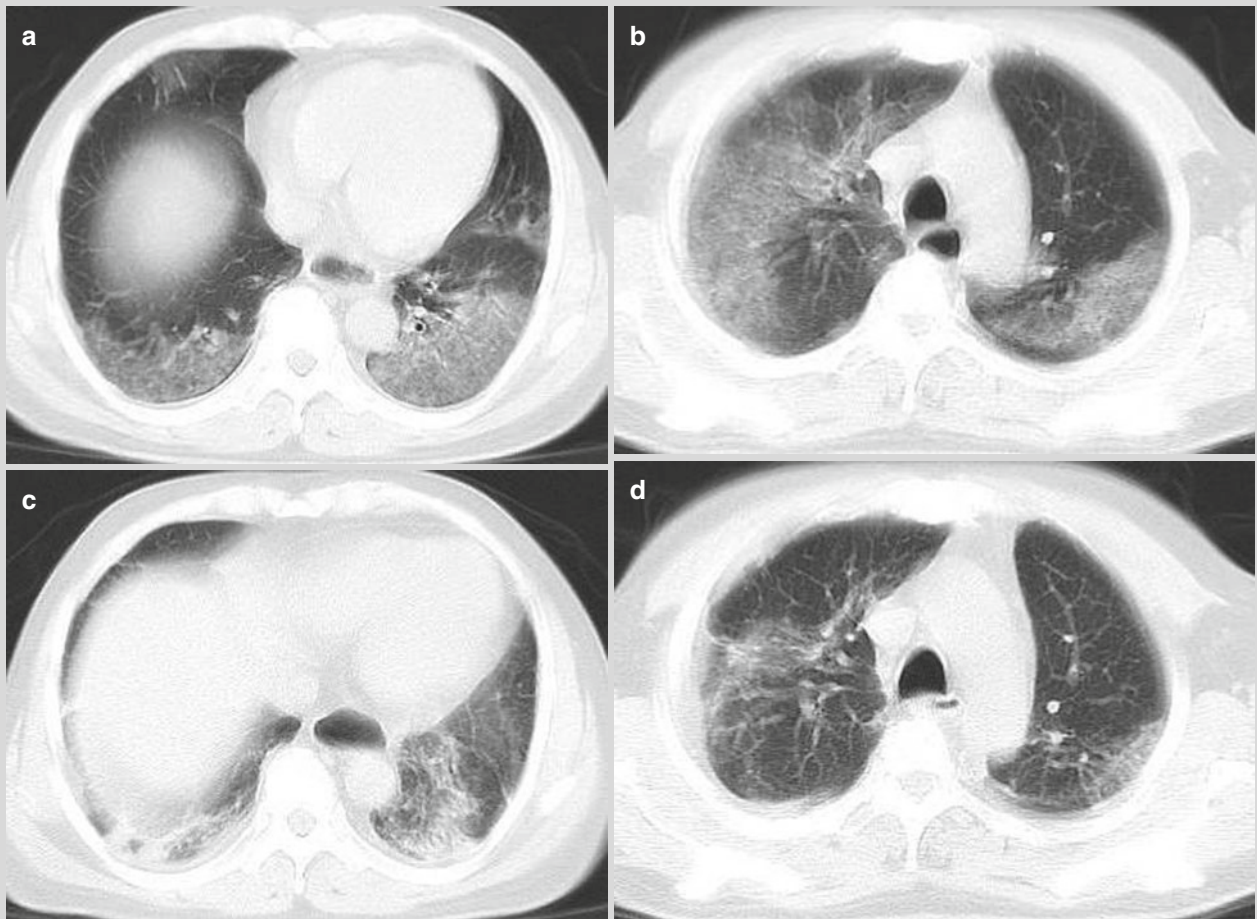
CT scan showed multiple flakes of ground glass opacity in both lungs that closely adhered to the pleura (a, b). Reexaminations after treatment for 27 days (c) and 36 days (d), the lesions were
